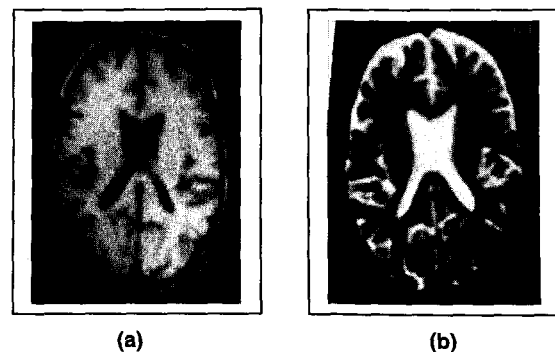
(a)  $T_1$  weighted MR image of brain of an AD patient, (b)  $T_2$  weighted MR image of brain of the same AD patient.
